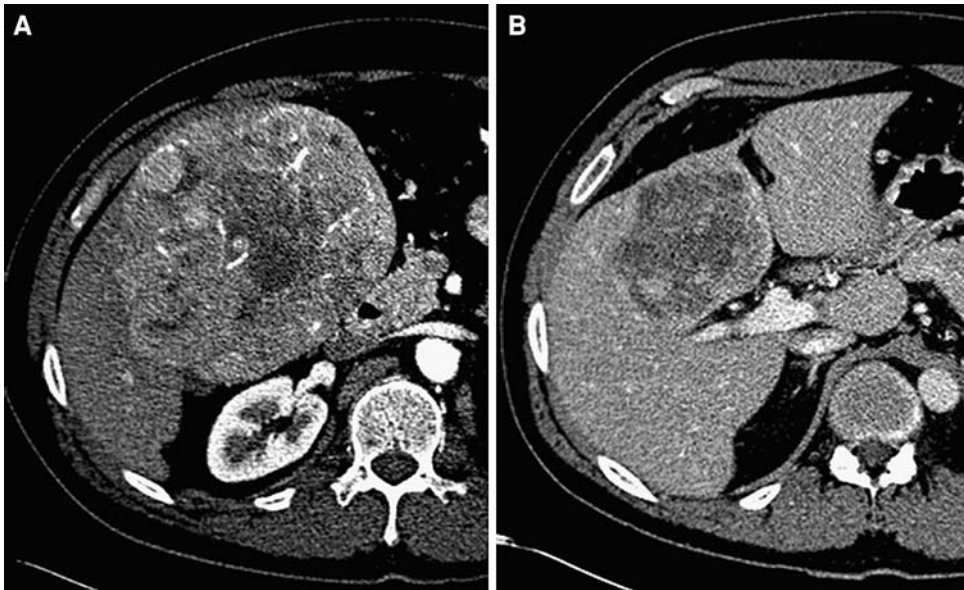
(A) Pre-treatment contrast-enhanced CT demonstrates a large, 17 cm, heterogeneously enhancing exophytic hepatoma. (B) Post-treatment contrast-enhanced CT demonstrates significant reduction in tumor size and enhancement. The tumor now measures 7 cm.
